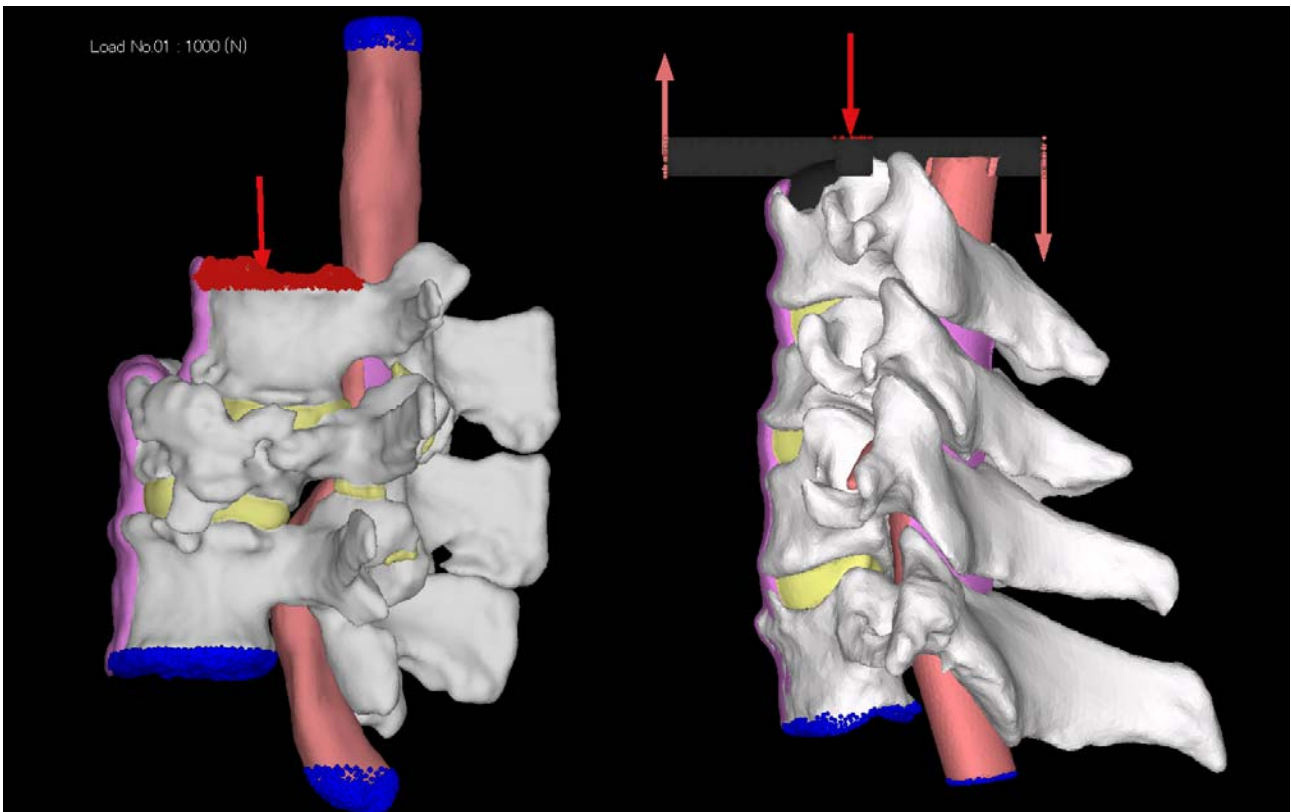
Analytical lumbar and cervical model. Left: A 3D model of the L2-4 vertebrae, intervertebral discs, and dural canal reconstructed from CT data. For the load, 1,000 N was loaded in the gravity direction on the cranial-side end plate of L2. Right: A 3D model of the C4-7 vertebrae, intervertebral discs reconstructed from CT data and the dural sac from MR myelography data. 3.0 degree was loaded in extension on the disc of C5-6.
